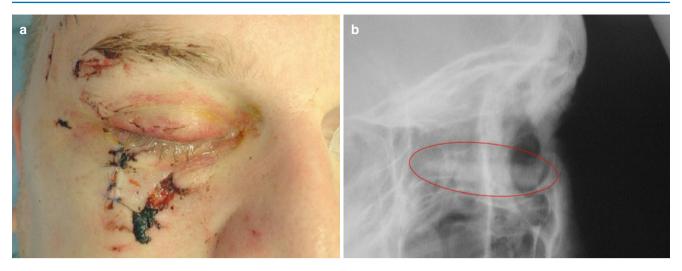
Patient presenting having been hit in face with beer glass. Glass seen on plain film passing along the floor of orbit, below the globe. Fortunately the globe was intact (a, b). The *red circle* highlights the glass fragment
